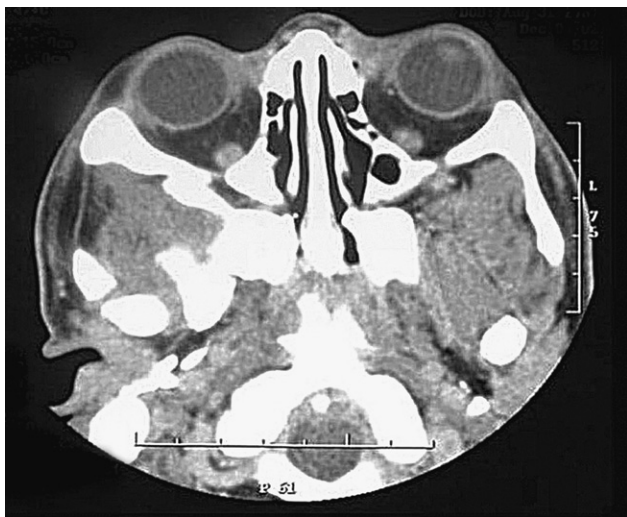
Coronal CT scan of the head and neck without contrast demonstrating hyperostosis and marrow obliteration of the maxillofacial bones.
